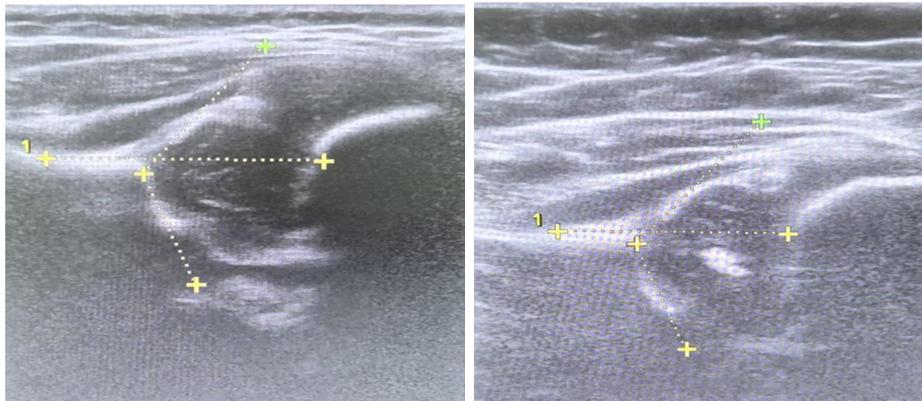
Hip ultrasound at 5 weeks and 5 months of age.
